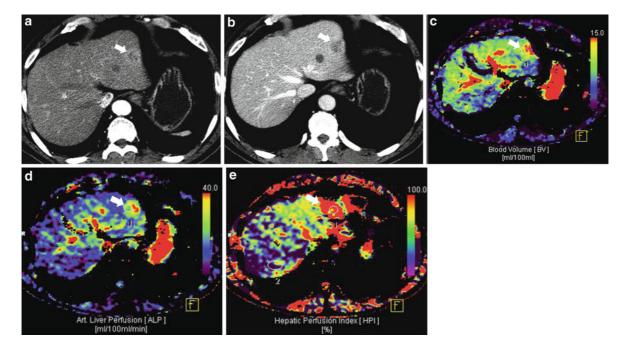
Perfusion CT for quantification of tissue perfusion in patient with HCC in the left lateral segment of the liver. a Arterial phase CT scan shows a 2 cm hyperenhancing HCC (*arrow*) in the left hepatic lobe. b Portal phase CT scans
